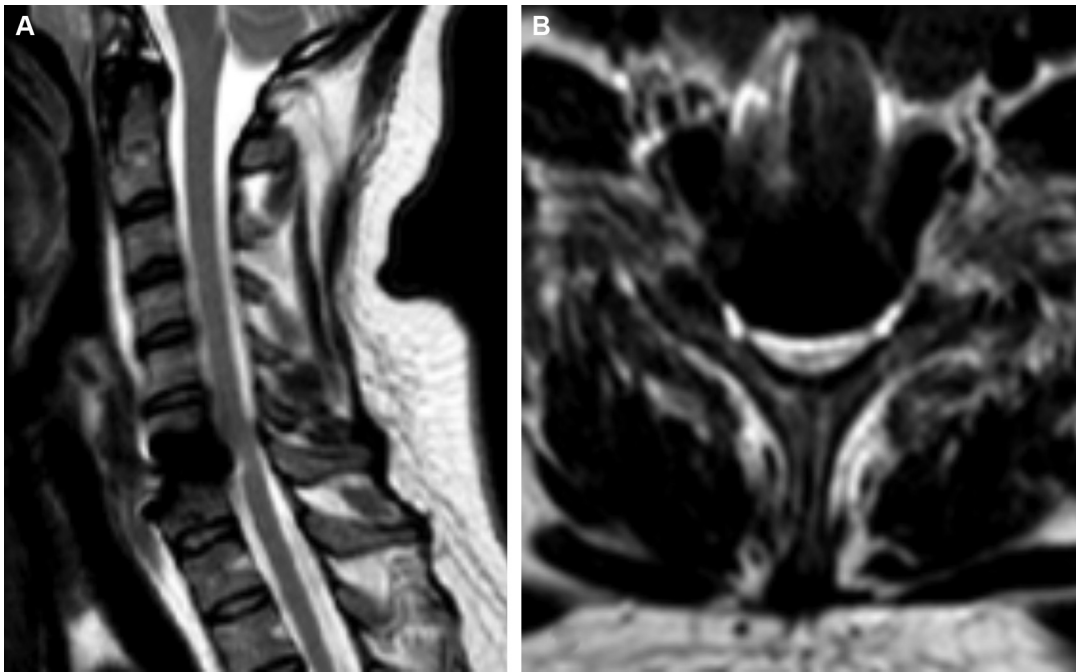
MRI of the spinal cord, T2-weighted sequence: artefacts generated by the prosthesis on sagittal (A) and axial (B) views.
